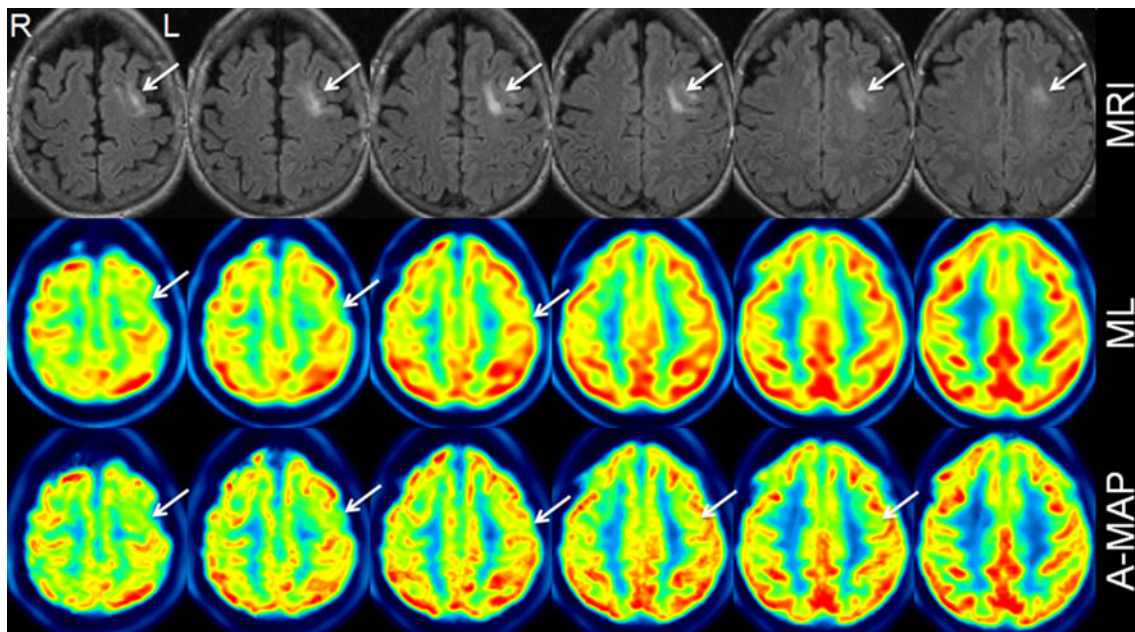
FLAIR, ML and A-MAP reconstructed FDG-PET images from a patient with FCD in the left superior frontal cortex (patient 8). Blinded visual interpretation of ML FDG-PET images was negative. A
